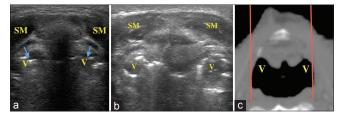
(a and b) Oblique axial view, just above the level of hyoid with cephalad angulation of linear transducer demonstrating sonoanatomy of valleculae on either side. Two different patterns were appreciated. (a) Linear hyperechoic air mucosal interface on either side of midline and (b) Air-filled rounded paired structures on either side of midline. (c) Corresponding oblique axial computed tomographic section (red lines – representing limit of ultrasound scan extent) V, valleculae; blue arrows, hyperechoic air mucosal interface of anterior wall of valleculae; SM: suprahyoid muscles
